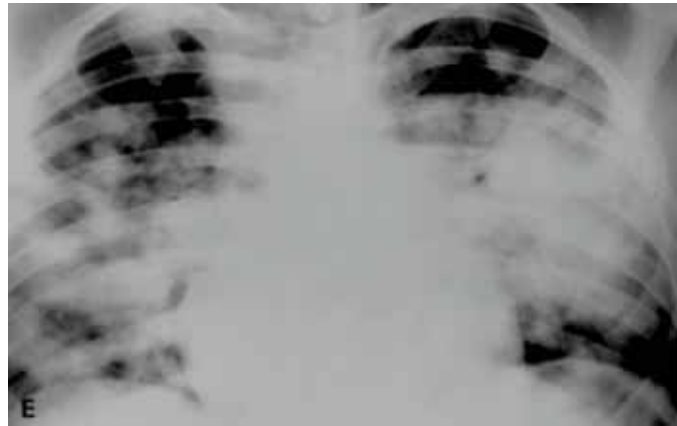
Chest radiography demonstrating multiple lung metastases secondary to cancer
